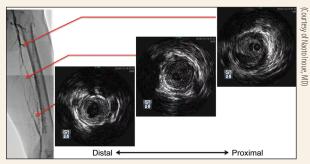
Intravascular ultrasound revealed true lumen crossing through the CTO after penetration using the Wingman.
